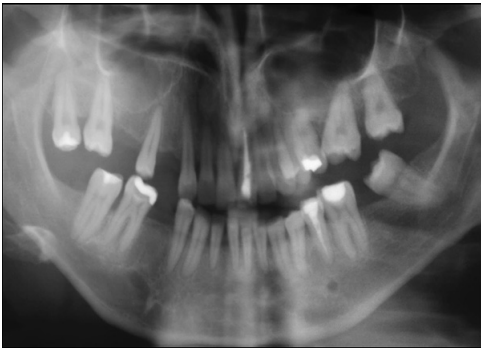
Orthopantomography after the orthodontic treatment
